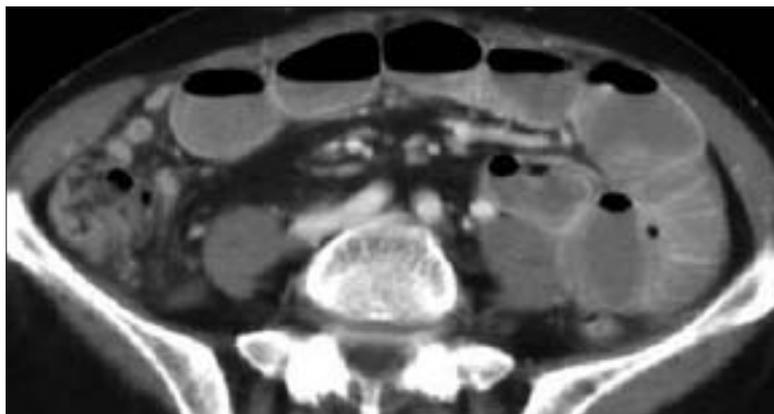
Axial CT image shows distended ileum loops in a case of Crohn's disease and peri-cecal inflammatory changes.
